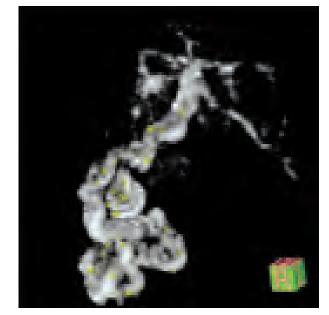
Umbilical cord by three-dimensional magnetic resonance imaging (3D MRI) angiography. By 3D MRI angiography, whole shape of umbilical cord is delineated clearly. We can measure its length from this image
